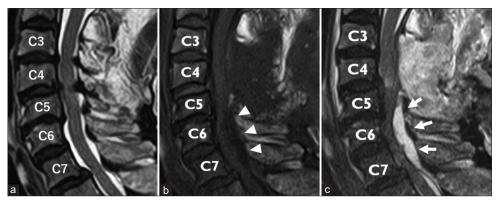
Magnetic resonance image before and after the surgery. (a) Cervical spinal stenosis was found in the T2-weighted image, sagittal section, and the diagnosis of cervical spondylosis was made; therefore, the patient performed the C3 to C5 laminectomy. (b) Four days after the surgery, the mass occupying the dorsal epidural space (arrowhead) was well demarcated and low-intensity in T1-weighted and (c) homogeneously hyper-intensity in T2-weighted image (arrow).
